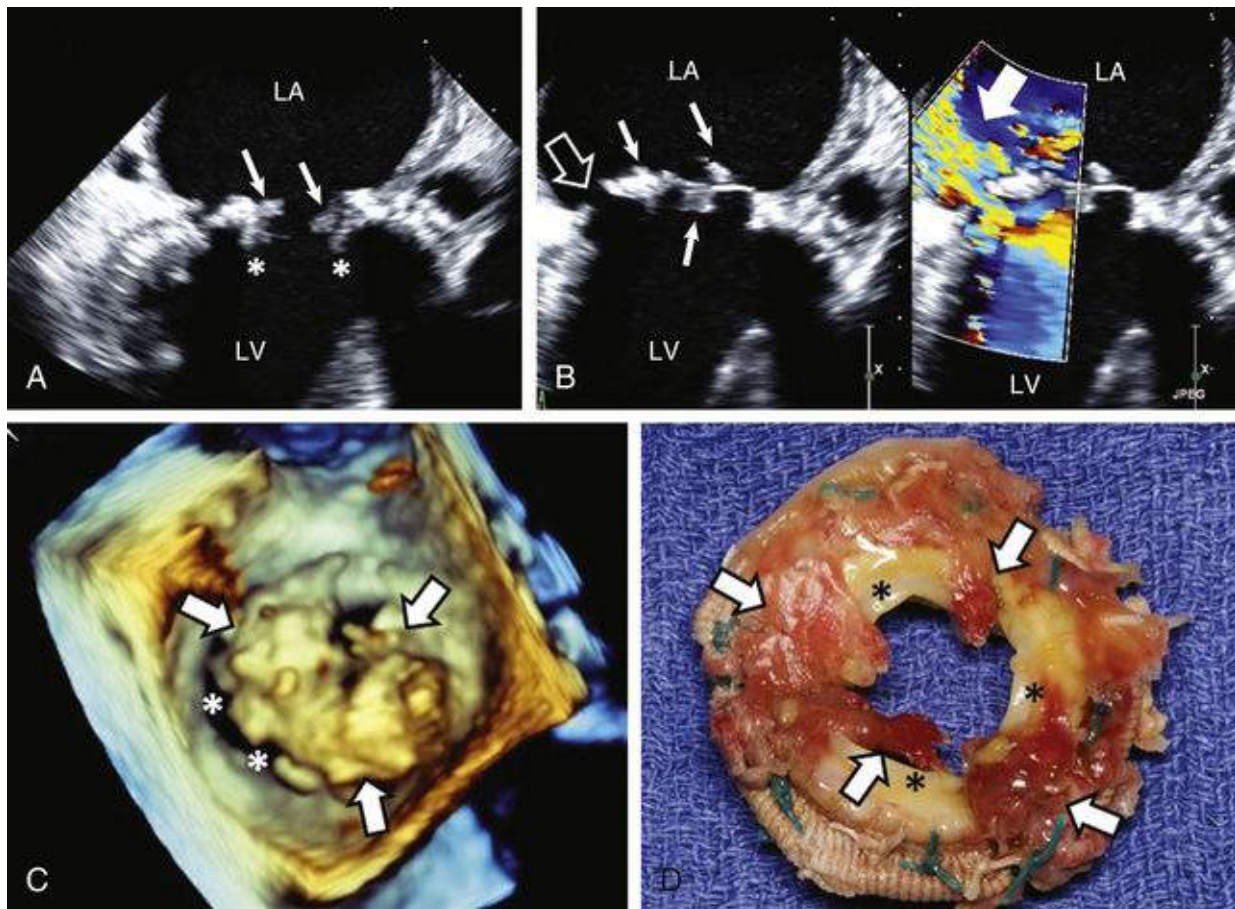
Infective endocarditis of a mitral bioprosthesis. A, On transesophageal echocardiography (TEE), multiple vegetations (*arrows*) can be seen within the inflow orifice of the bioprosthesis (*) during diastole. B, Left, During systole, a zone of inferolateral periannular prosthetic dehiscence (*large open arrow*) is evident with rocking motion of the prosthesis. Vegetations are present on the closed bioprosthetic leaflets and prosthetic annulus (*small arrows*). Right, Color Doppler image shows severe, eccentric periprosthetic mitral regurgitation (*large white arrow*) emanating from the zone of periannular dehiscence. LA, Left atrium; LV, Left ventricle. C, Three-dimensional TEE view from the left atrium shows an extensive mass of vegetations encompassing the periannular margins (*arrows*), which was not fully appreciated by two-dimensional imaging. A large crescentic zone of periannular dehiscence (*) is well visualized. D, The surgically excised mitral bioprosthesis shows extensive vegetations (*arrows*) attached to the atrial aspects of the prosthesis. Pannus ingrowth (*) into the prosthetic orifice also is present.
